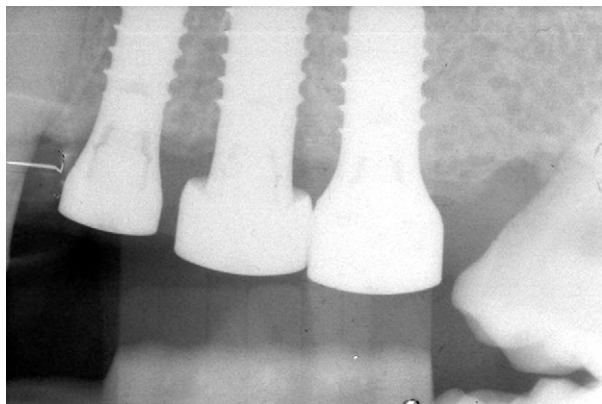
Radiograph showing oversized healing cap.
